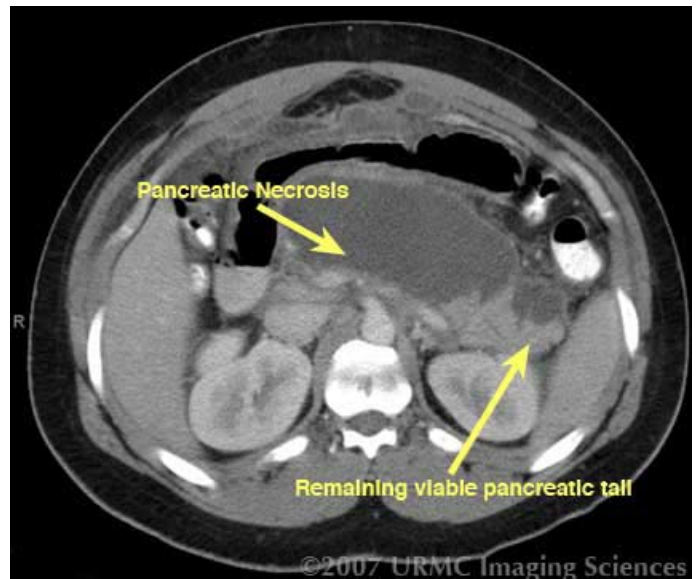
Axial CT image demonstrates necrosis of the pancreatic body with residual normal, enhancing pancreatic tail.
